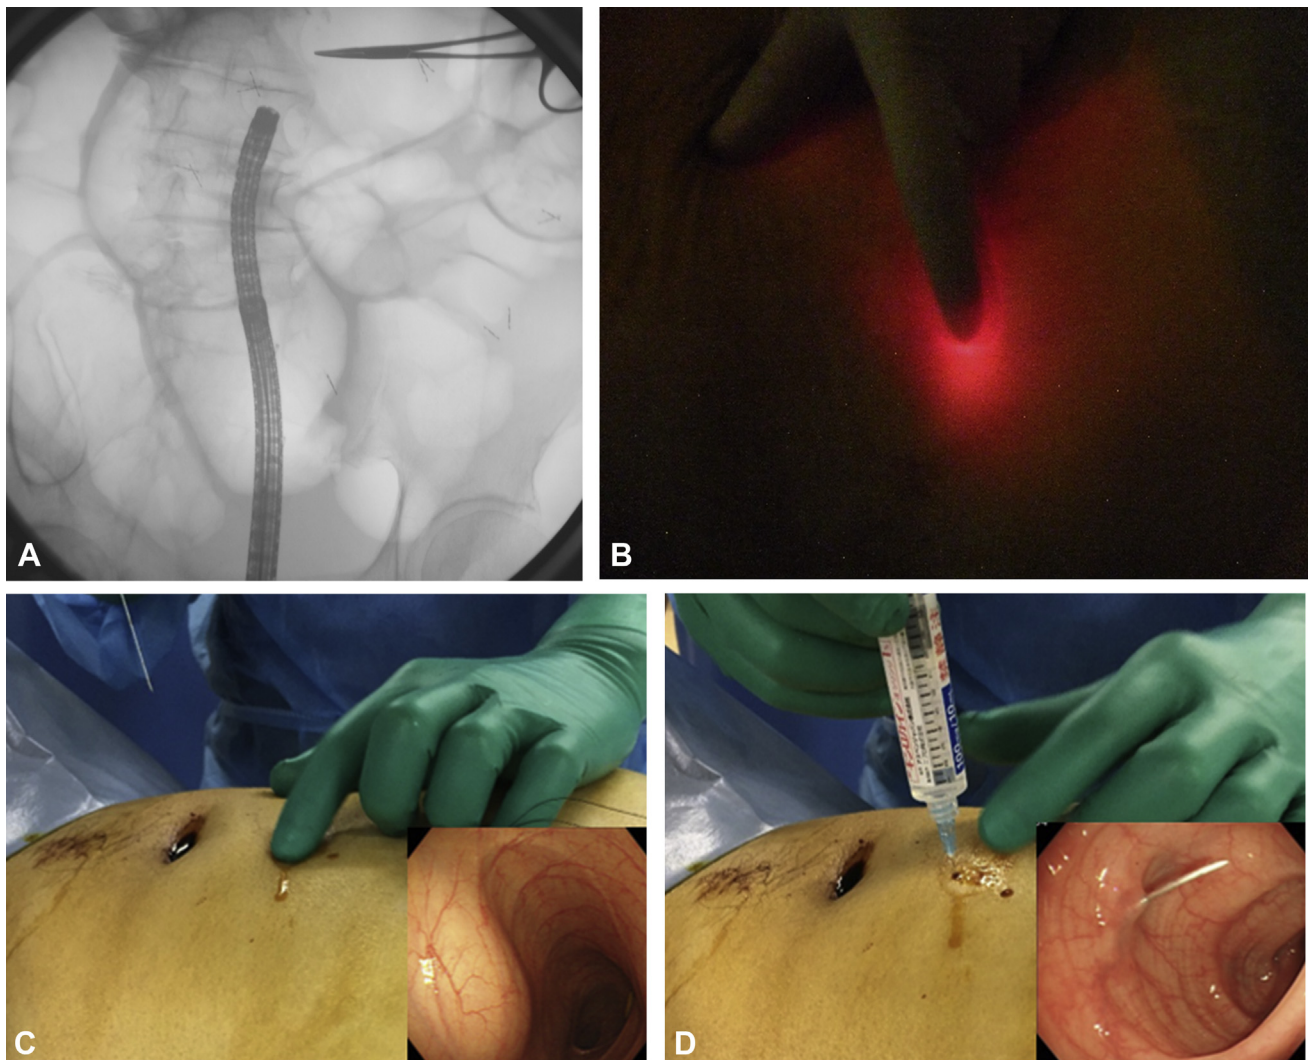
A, Using radiography, we confirmed the position of the tip of the colonoscope. B, The site for puncture was confirmed by transmitted illumination. C, When the abdominal wall is pressed with a finger to determine the site for puncture, the wall of the sigmoid colon is pressed. D, Exploratory puncture with a 23-gauge needle into the sigmoid colon.
